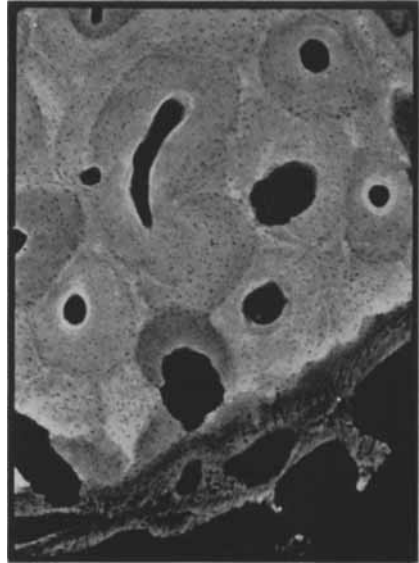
A comparison of the micro-radiograph (a), the auto-radiograph in vitro (b) and the examination in polarized light (c). The lower the degree of mineralization in the micro-radiograph, the higher the degree of uptake of radioactive Ca.
